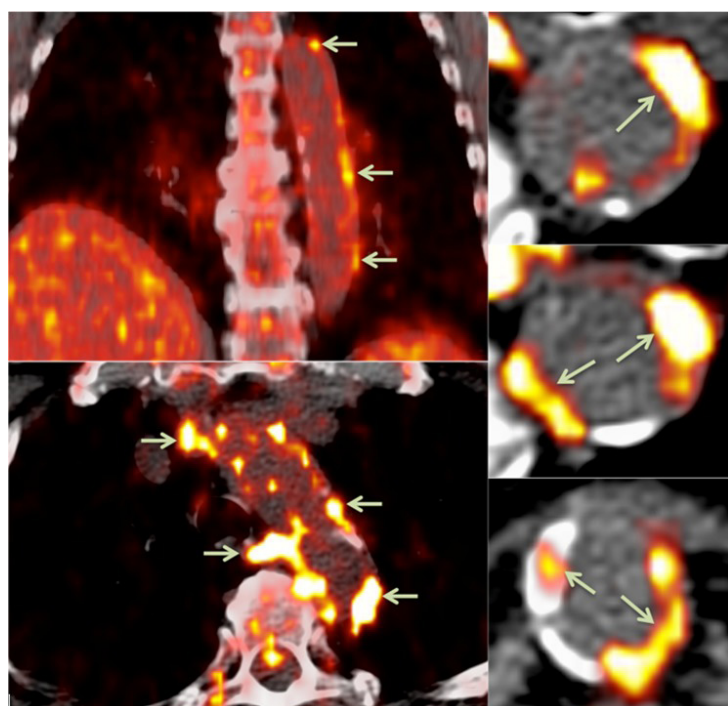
FDG-PET/CT indicating regions with focal radiotracer uptake in the descending aorta vessel wall (arrows). Reprinted from Evan, Tarkin, Chowdhury, Rudd (2016)¹¹, Current Atherosclerosis Reports.
